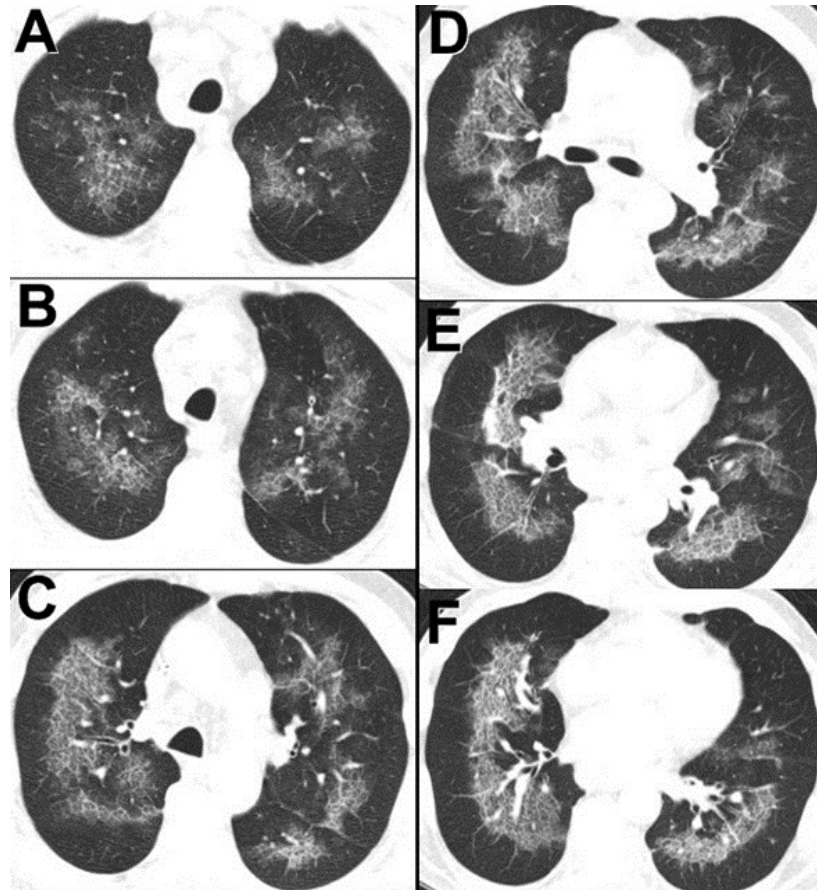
Thoracic CT scan.
